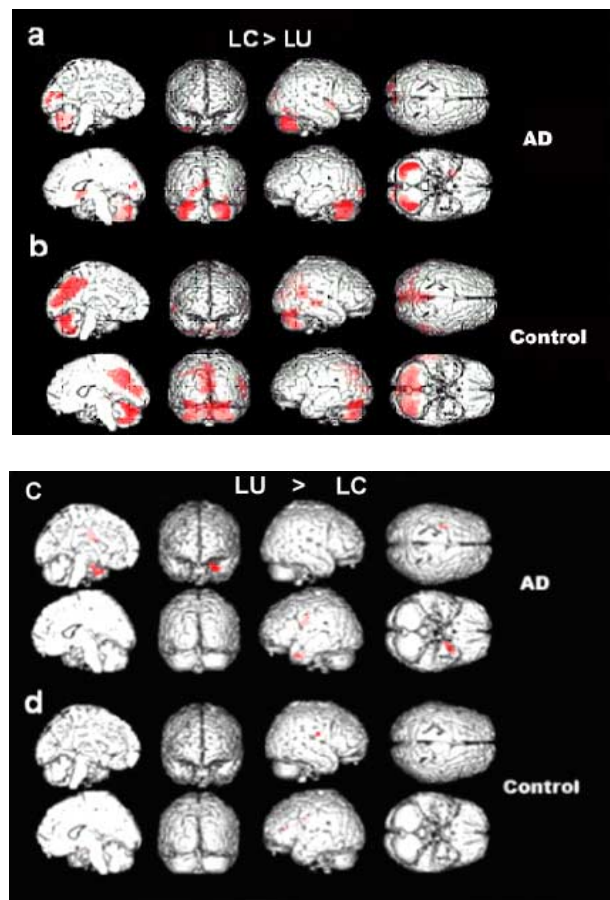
SPM demonstrates the difference in rCBF distribution between the LU and LC images as indicated by the colored areas superimposed on volume rendering of standard 3-dimension anatomic template of magnetic resonance images (3D Render). The contrast, LC > LU, reflects that (a, b) the pattern of rCBF distribution is less in LU images or high in LC images, whereas, the contrast, LU > LC, reflects that (c, d) the pattern of rCBF distribution is less in LC images or high in LU images.
